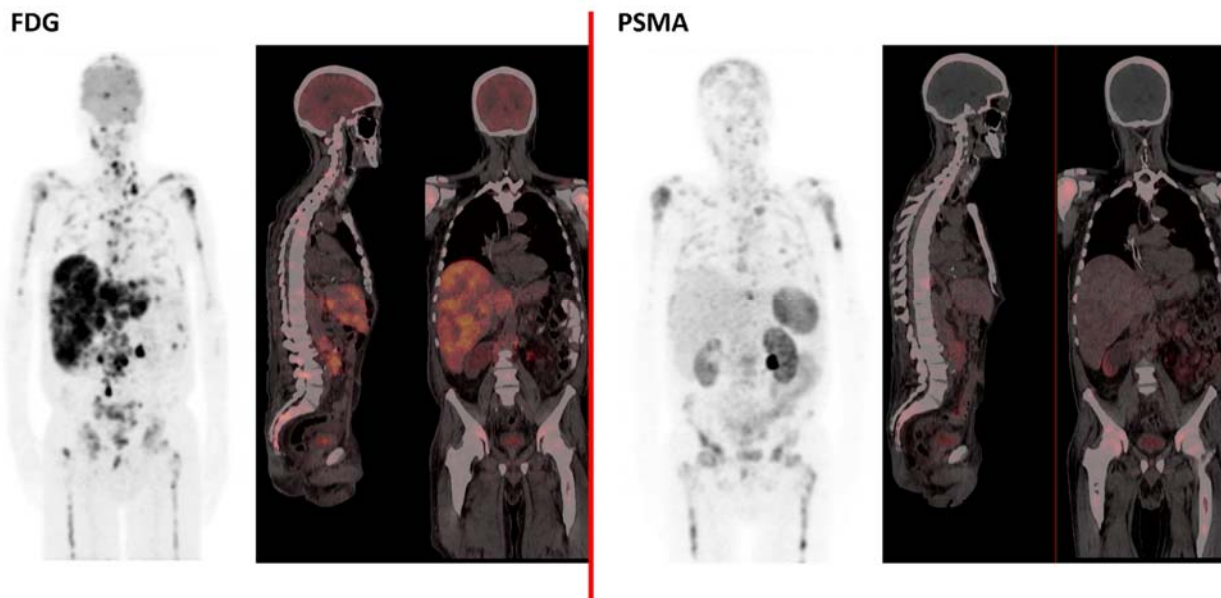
FDG PET and ^{68}Ga -PSMA PET imaging of a patient with multiple lines of prostate cancer therapies. Prior to receiving PSMA-targeted radioligand therapy, he had received treatment with docetaxel, abiraterone, and cabazitaxel. He developed biochemical (rise in serum PSA level) and clinical (worsening disease-related symptoms) evidence of disease progression while on PSMA-targeted radioligand therapy. ^{68}Ga -PSMA PET imaging shows declining tumor avidity despite evidence of disease progression by clinical and biochemical criteria. FDG PET imaging was obtained to evaluate for loss of PSMA expression in prostate cancer lesions. Images show extensive FDG-avid liver and skeletal metastases. PSMA PET imaging demonstrates avidity in fewer skeletal metastatic lesions. This case showcases tumor heterogeneity that may occur in advanced prostate cancer and the role of combined FDG PET and PSMA PET imaging for tumor delineation.
